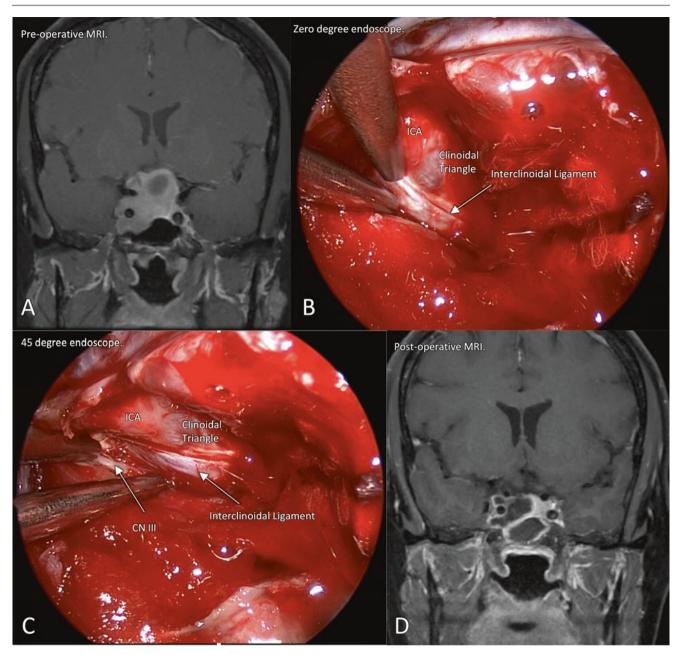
(a–d) Clinical example of pituitary macroadenoma invading the superior compartment. (a) Preoperative MRI showing large adenoma, with cavernous sinus invasion (both superior and inferior compartments are invaded). (b) Intraoperative view using a zero-degree endoscope
